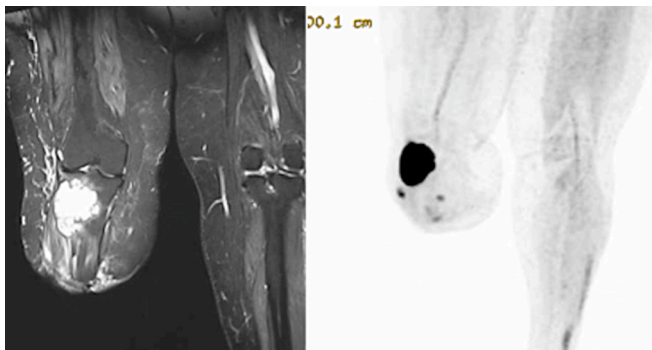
(Left) MRI and (right) PET scans demonstrating recurrence affecting the right leg stump site following previous *trans*-tibial amputation for recurrence despite 7 cm surgical margin.
